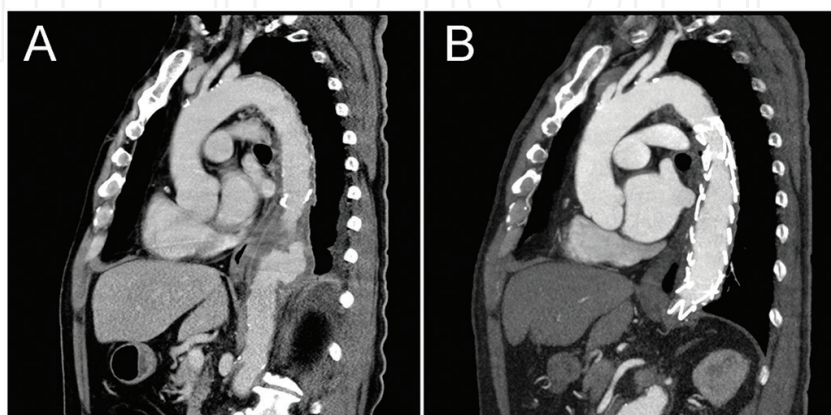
(A) Infected descending thoracic aortic aneurysm in a 70-year-old male patient (B) Oral antibiotic treatment continued for 1 year after TEVAR and CT angiography 2 years after TEVAR showed no residual aneurysm or periaortic infection. No adjunctive procedure was ever done for this patient.
